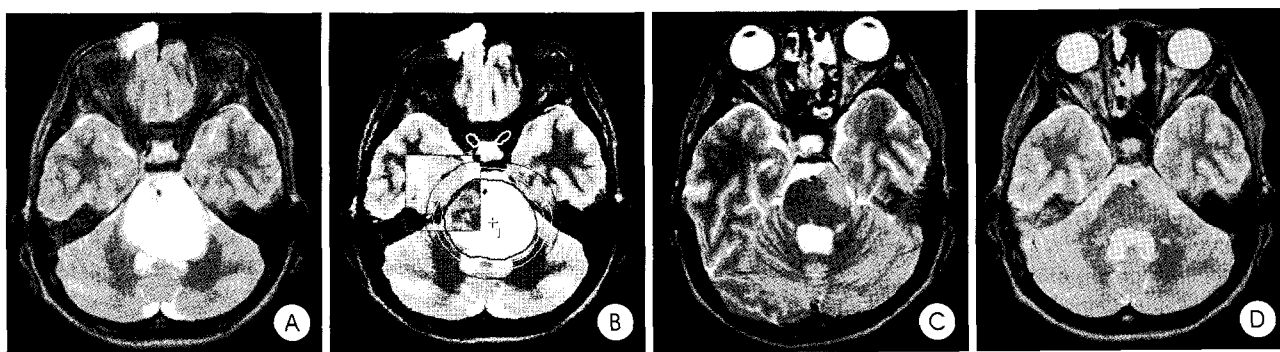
A : Pre-fractionated stereotactic radiotherapy brain T2-weighted magnetic resonance(MR) image shows the growth pattern of diffuse intrinsic type. B : Dosimetry of fused image of T2-weighted and T1-weighted gadolinium enhancement MR images. Radiotherapy dose was 52.5Gy given in 30 fractions of 1.8Gy isodose at 80% (applied prescribed dose line is painted yellow). C : One month after fractionated stereotactic radiotherapy, T2-weighted MR image demonstrates marked decrease size of the tumor. D : Three months after fractionated stereotactic radiotherapy, MR image shows stable residual mass.
